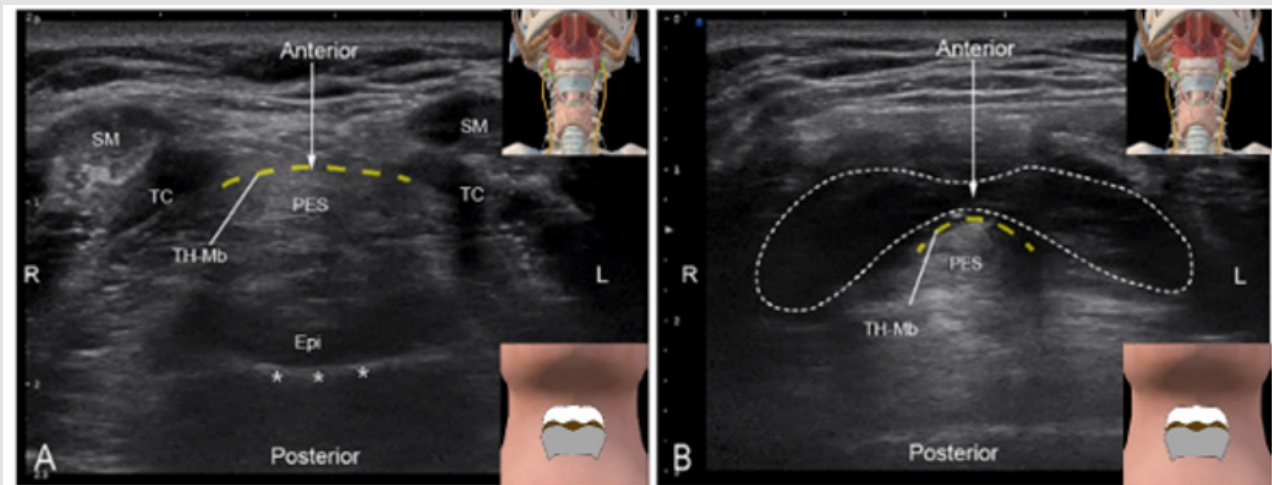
Transverse sonography of the modified ultrasound-guided anterior superior laryngeal nerve block (UG-MAA-SLNB). (A) Midline transverse plane ultrasound image at the level of the thyroid notch. The thyrohyoid muscle (TH-Mb) is identified on ultrasound, bounded anteriorly by the thyroid cartilage (TC) and posteriorly by the posterior belly of the digastric muscle (PES). (B) During performance of SLNB via the modified anterior approach, lidocaine was injected into the space anterior to the TH-Mb. Lidocaine was visualized pushing the TH-Mb and rapidly diffusing into the lateral Para glottic space.
